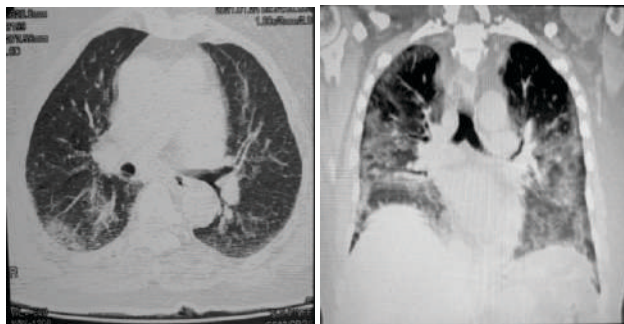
(a&b): Axial and Coronal Sections of HRCT-Chest showing Ground Glass Haze with Interlobular Septal Thickening of CORAD-3 Severity in Figure a and CORAD-4 in Figure b.
